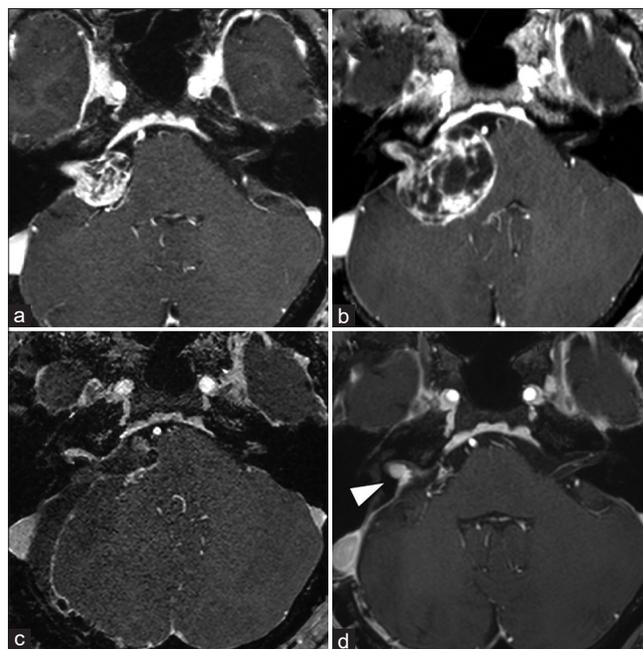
Imaging follow-up of the right CPA tumor. The right CPA tumor grew rapidly, with its maximum diameter expanding from 23 mm (a) to 35 mm (b) in 6 months, and the brainstem compression worsened. MRI also showed a marked increase in the size of the cyst. MRI: magnetic resonance imaging, CPA: cerebellopontine angle. To avoid persistent facial nerve palsy, we left a tiny tumor on the facial nerve while performing near total resection (resection rate: 99%) (c). Five months postoperatively, the right residual vestibular schwannoma in the internal auditory meatus had grown, so stereotactic radio surgery was performed for the recurrent lesion (d, arrow).
